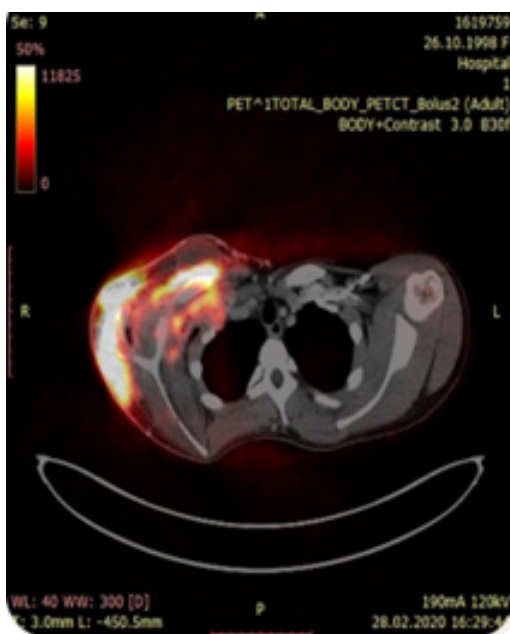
PET/CT of the thoracic region in axial projection.
